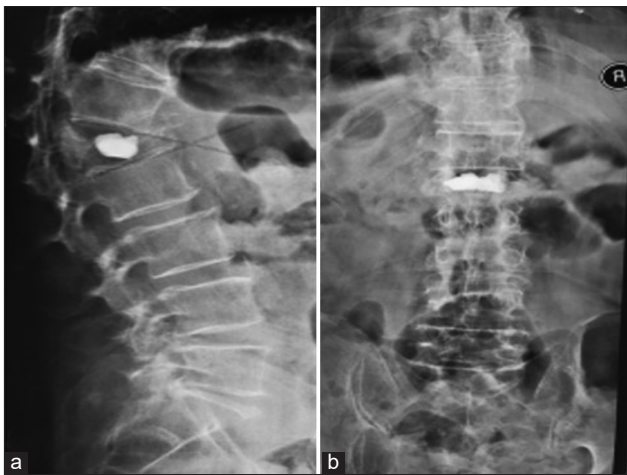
(a) Lateral plain radiograph shows refracture of cemented L1, note that the posterior compartment is pushed back associated with canal compromise and kyphosis, (b) anteroposterior lumbar X-ray demonstrates two cemented lumps.
